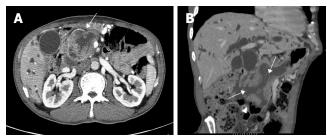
CT scan of case 2 demonstrating a 10 cm-sized cystic mass in pancreatic head (arrow) (A) and two communications between stomach and mass and between bulb and mass (arrows) and patulous ampulla of Vater (arrow head) (B).
